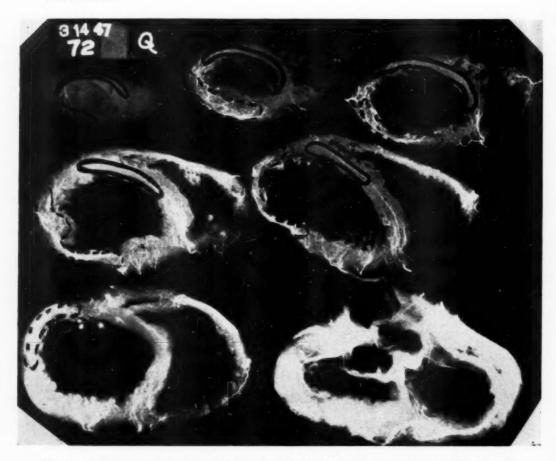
Roentgenogram of the injected heart in Case 151, showing recent anteroseptal infarct in solid outline and old, healed lateral infarct in broken lines.
